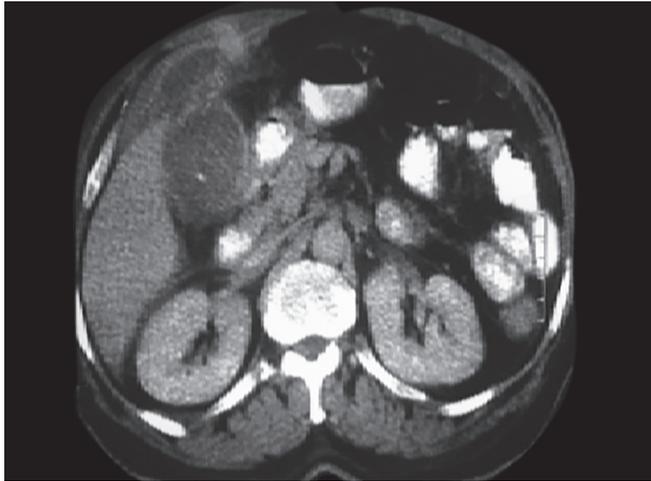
CT abdomen showing perforation in the gallbladder and cholecystocutaneous fistula
